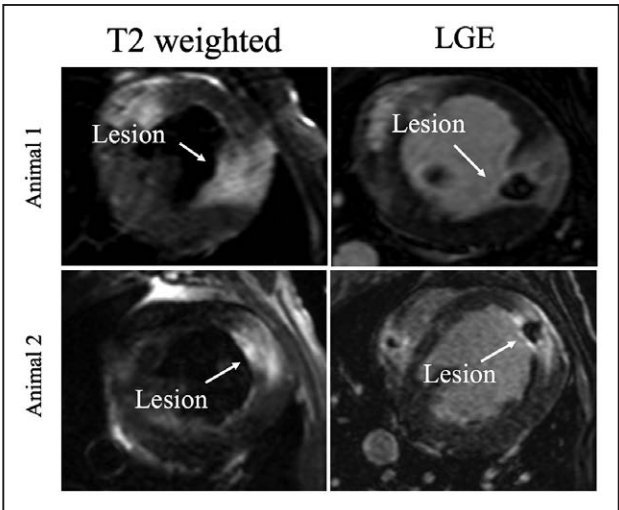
T2-weighted (T2w) and late gadolinium enhancement (LGE) images at wk 0 for 2 corresponding lesions.
